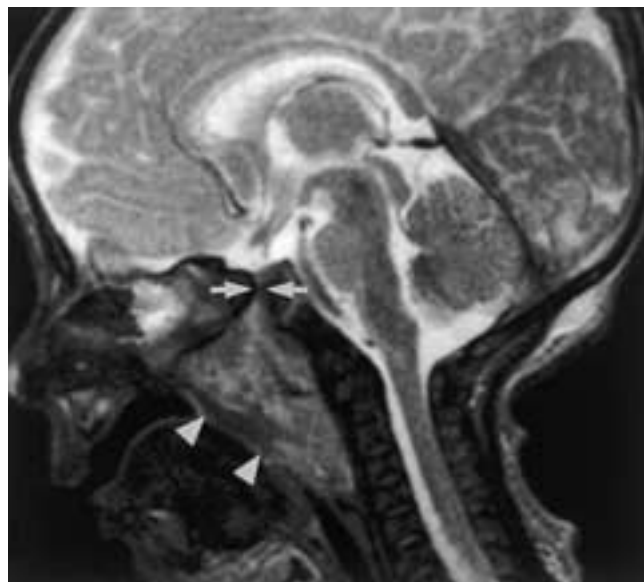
Neuroglial hamartoma in a 7-day-old boy with upper airway obstruction. Sagittal FSE T2-weighted MR image with fat suppression reveals a nasopharyngeal mass (arrowheads) that extends through a defect (arrows) in the sphenoid bone at the base of the pituitary fossa into the naso- and oropharynx. The mass is isointense with gray matter. The diagnosis was confirmed by biopsy.
